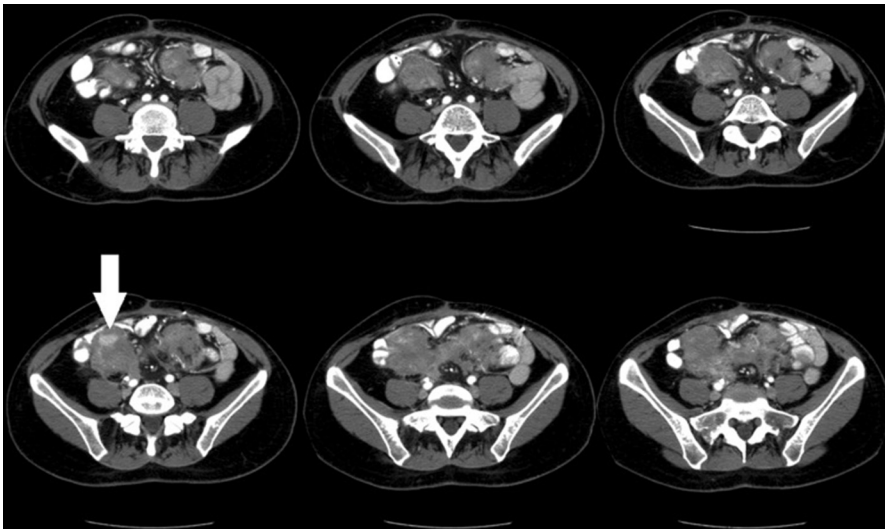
Sections from a contrasted abdominal computed tomography scan of a patient with FAP with intra-abdominal desmoid originating from the mesentery and retroperitoneum, including areas with fistulization with oral contrast within the desmoid (arrow). (From Hawkins AT, Wise PE. Colon cancer in hereditary syndromes. *Semin Colon Rectal Surg* 2016. <http://dx.doi.org/10.1053/j.scrs.2016.04.021>; with permission.)
